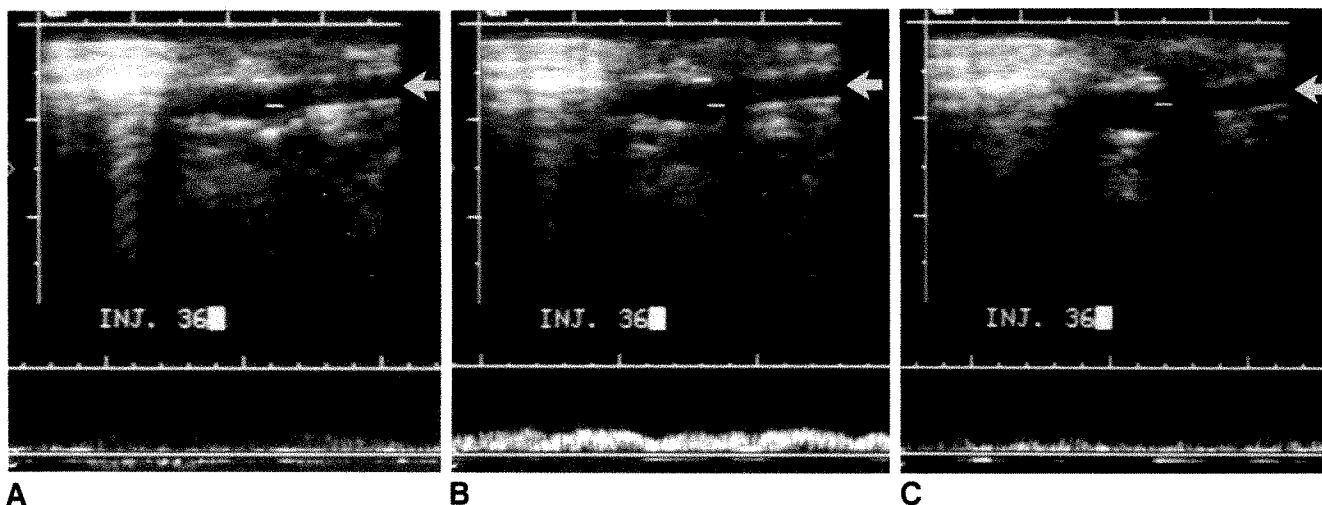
Longitudinal sonograms of portal vein (arrows) show effect of 0.5 ml of microspheres. This was the only injection less than 1.0 ml that was effective.
